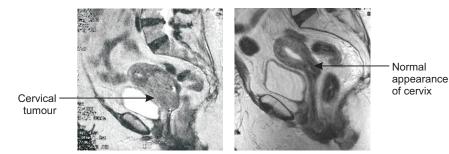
MRI scan showing patient with stage IIB squamous cell cervix cancer before and 3 months after radiotherapy.
